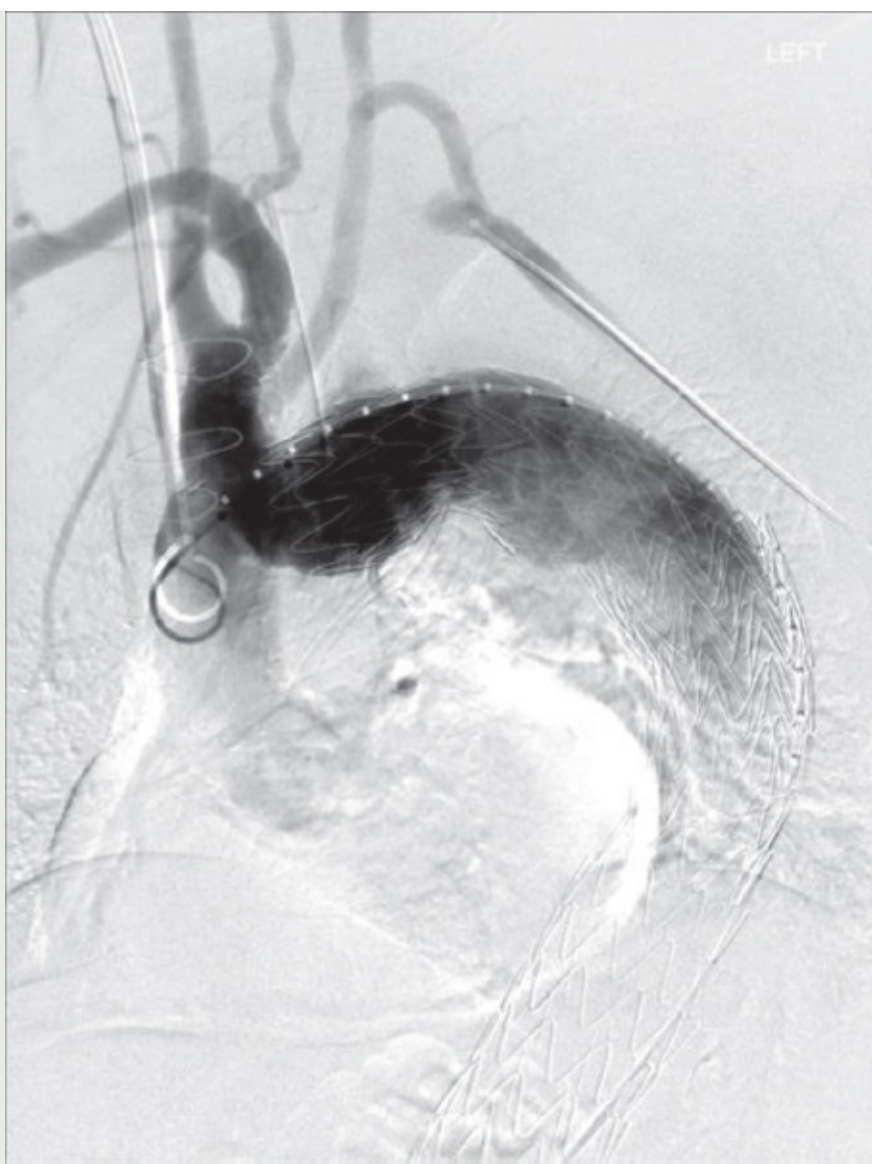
The distal component was then deployed approximately 3 cm above the celiac artery. Intravascular ultrasound was then used to find the orifice of the left carotid artery.
